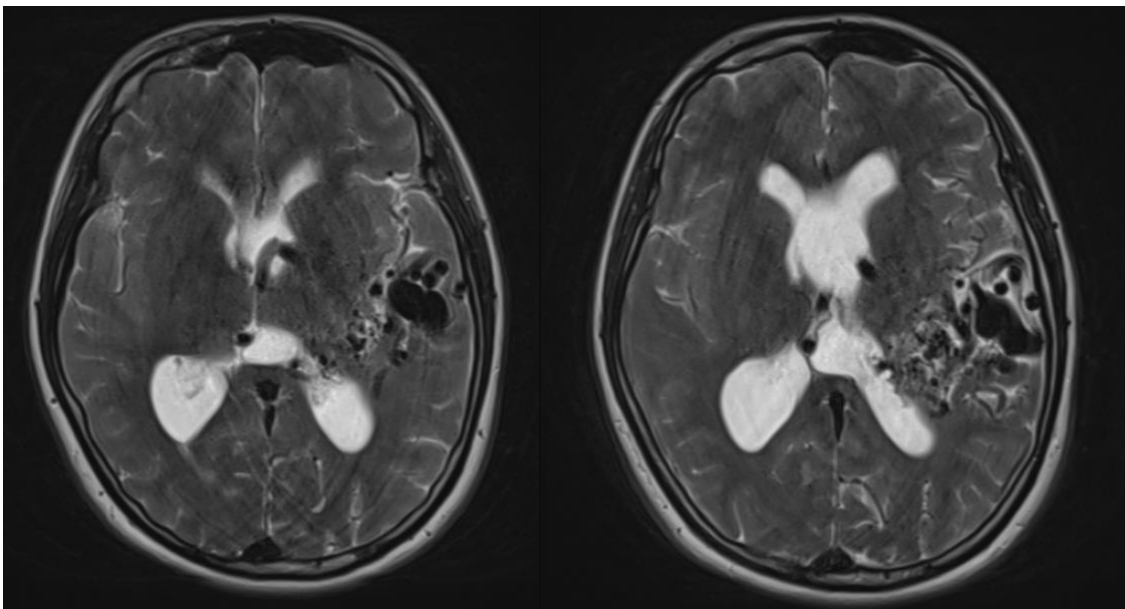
Magnetic resonance imaging brain scan axial T2W.
